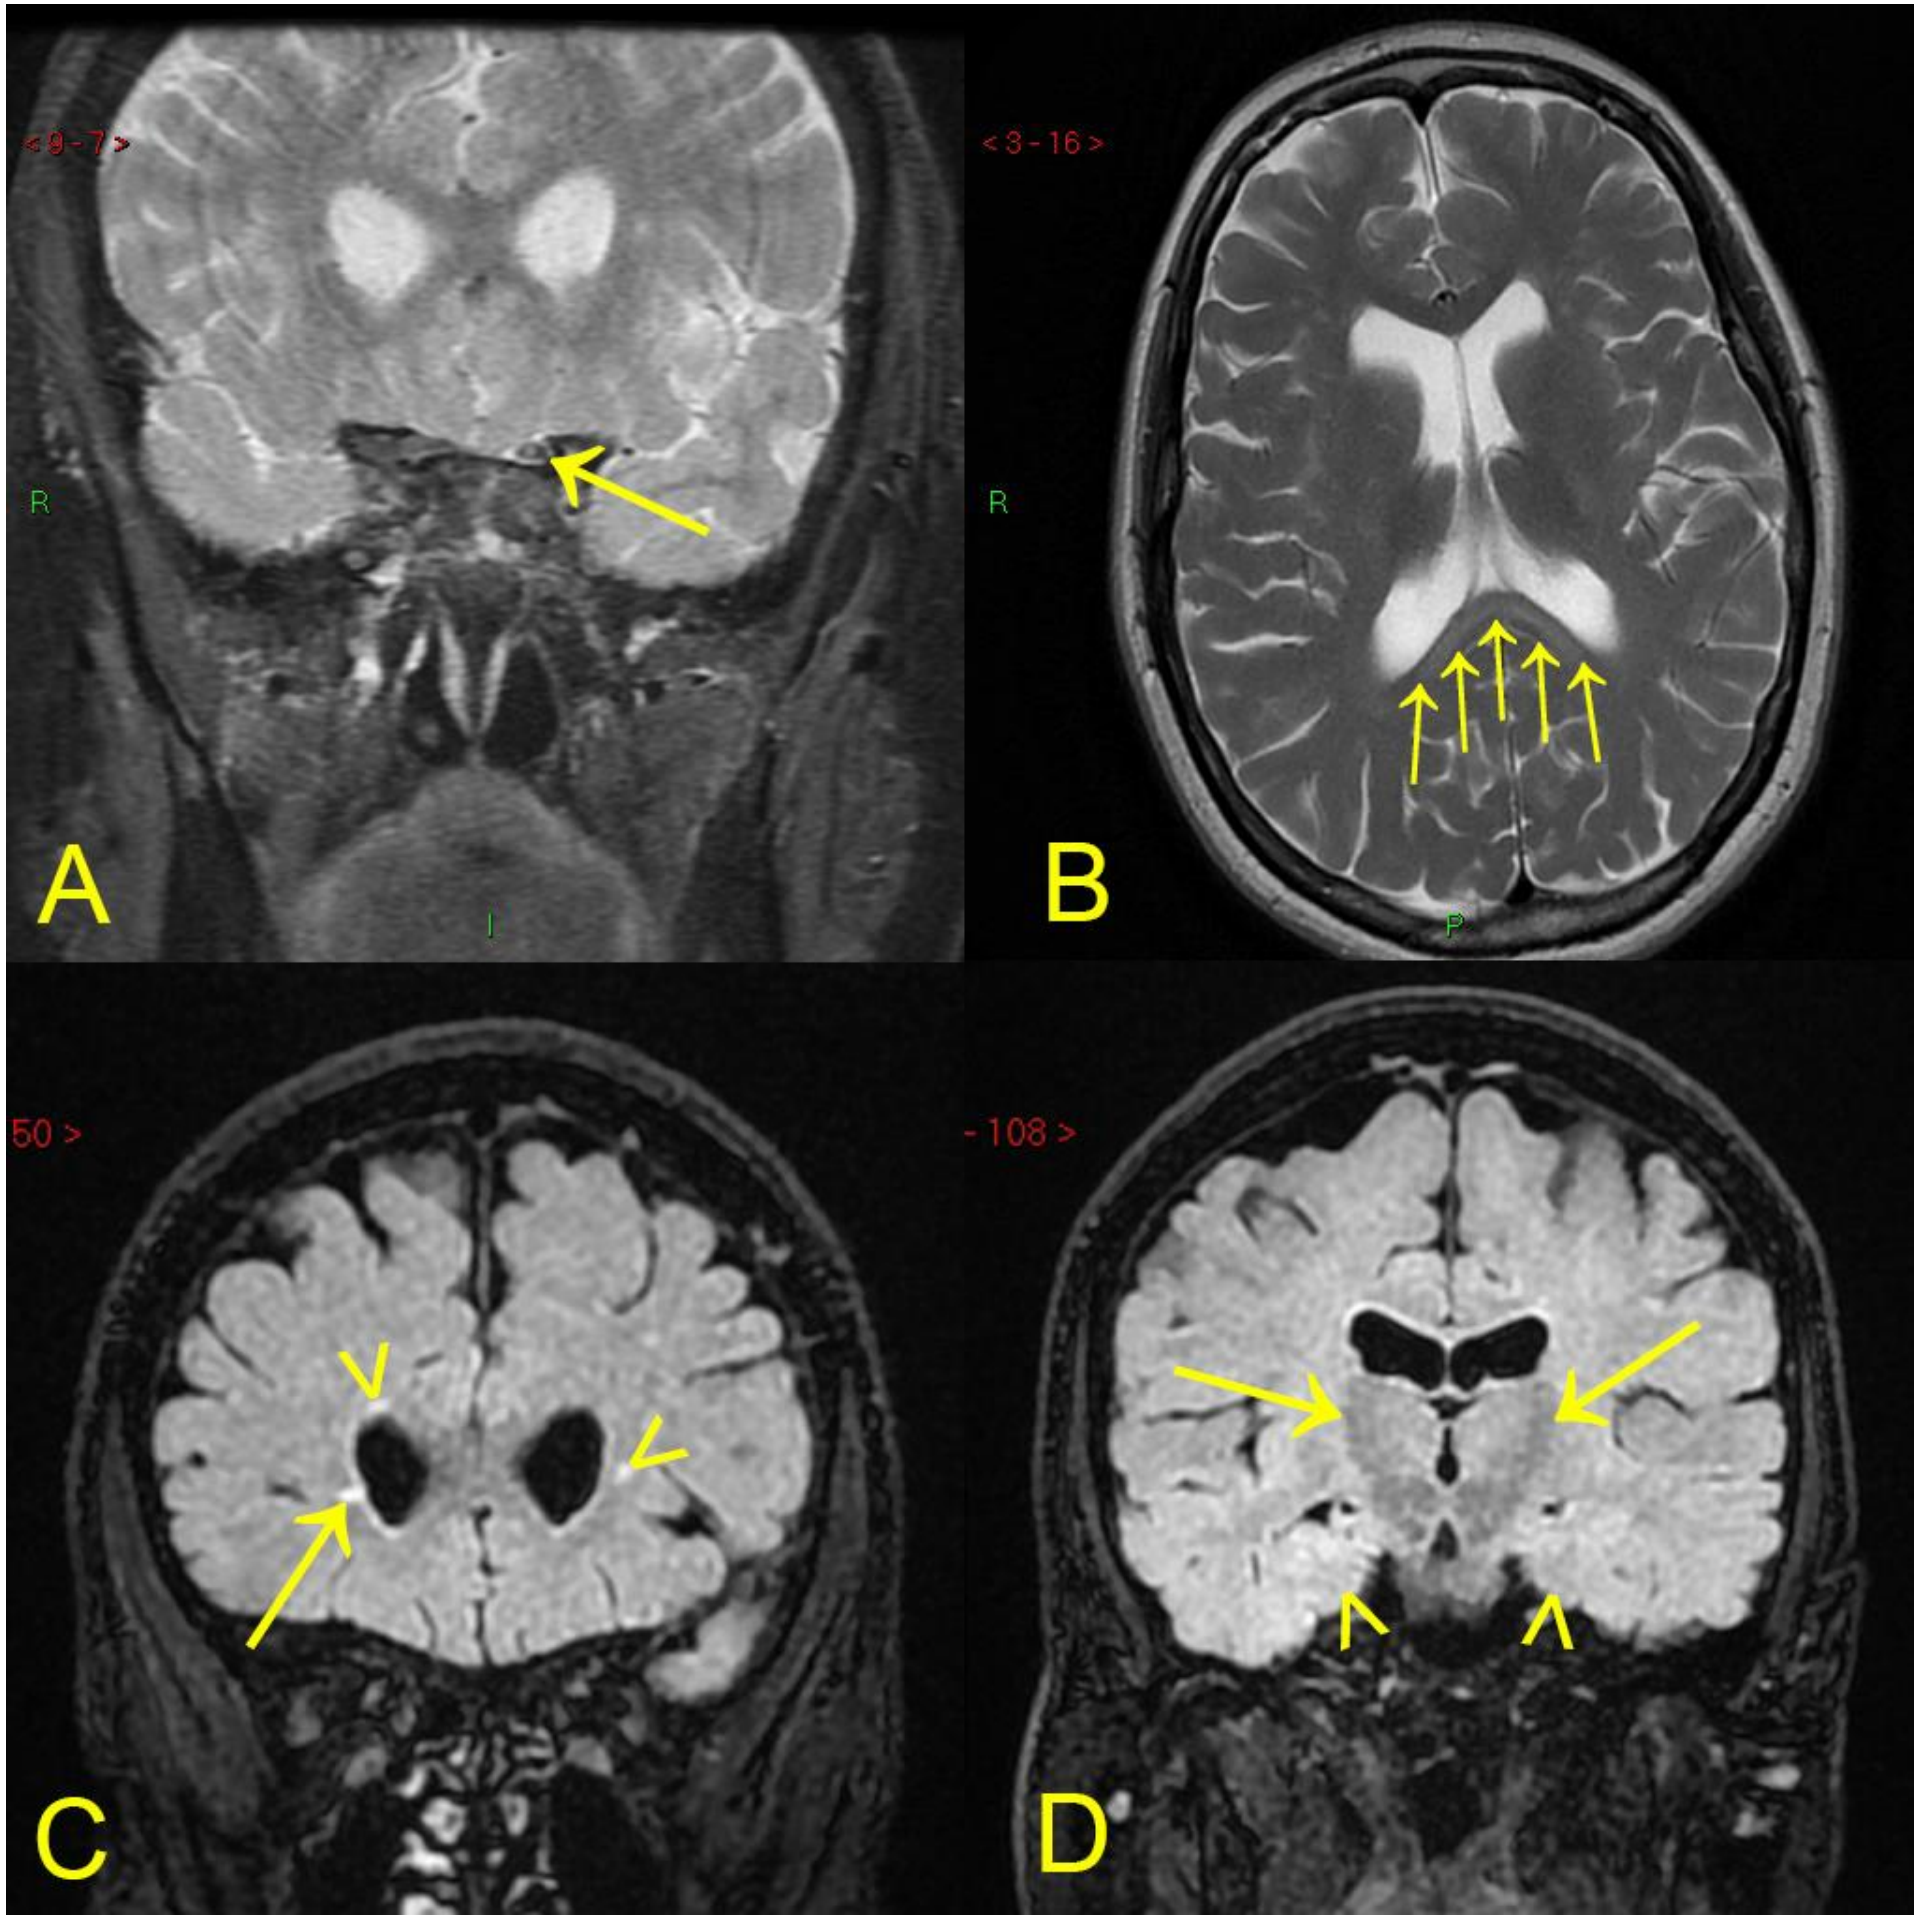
(A) Coronal STIR showing increased T2 signal in left pre chiasmal optic nerve (B) T2 axial showing increased T2 signal in splenium corpus callosum (C) FLAIR coronal showing white matter disease with one right periventricular T2 hyperintensity (arrow) and a few other focal T2 high signal lesions (arrowhead) (D) FLAIR coronal showing reduced T2 signal in both thalami (arrow) and increased signal in both hippocampi (arrowhead)
